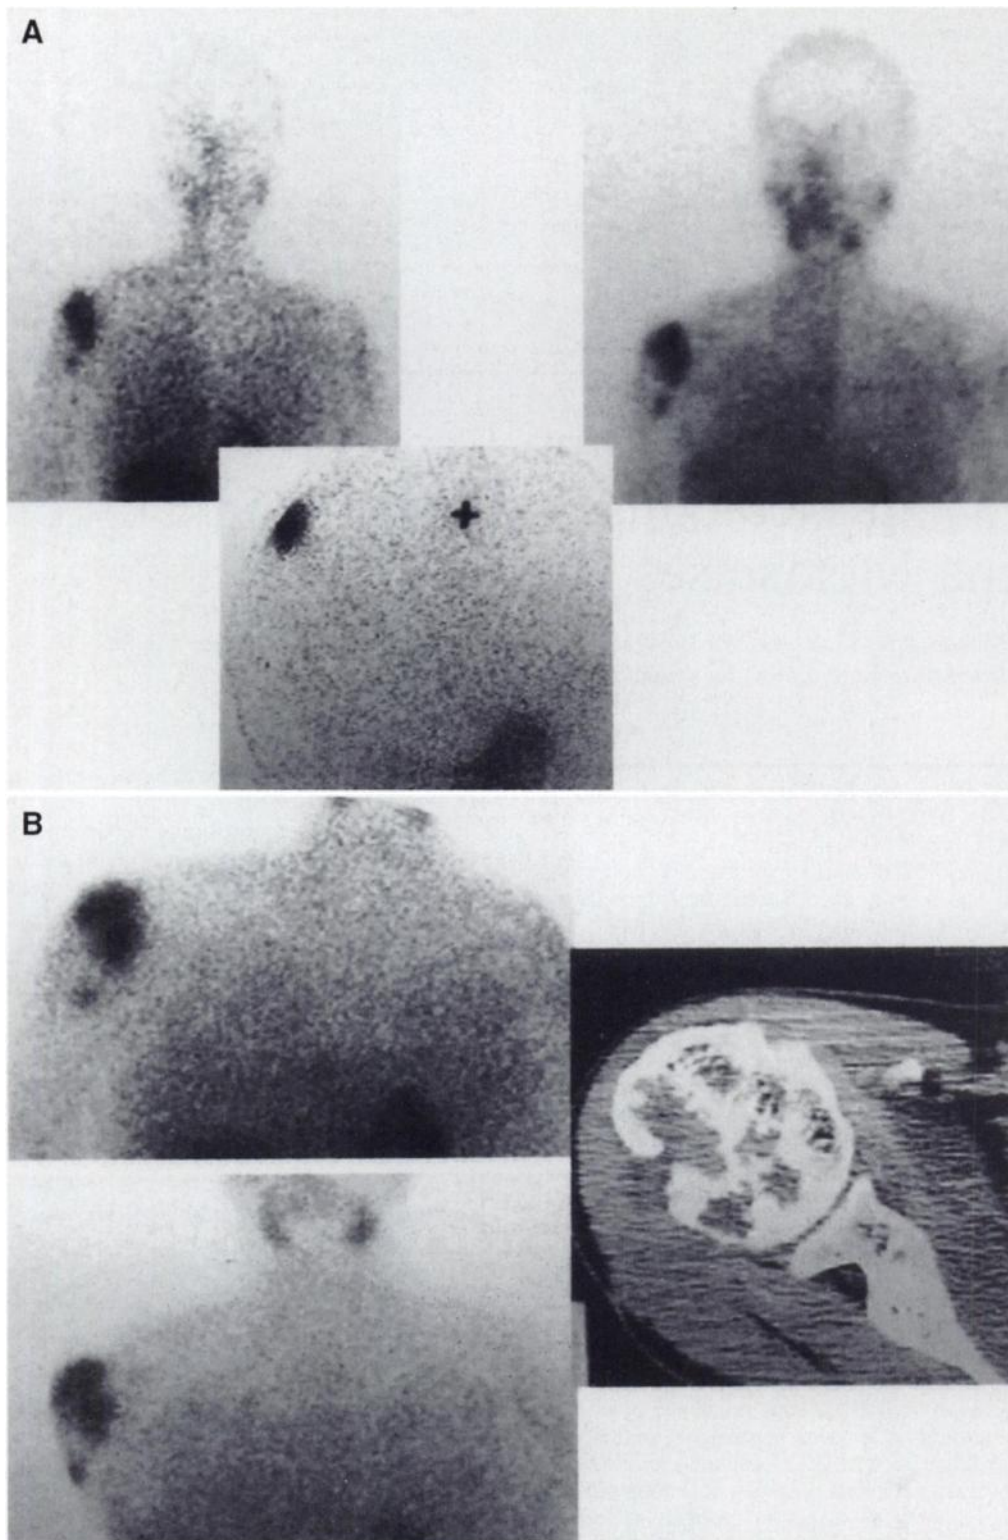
(A) A 31-yr-old woman with follicular thyroid carcinoma. Thallium-201 (left upper), ^{99m}Tc -tetrofosmin (right upper) and ^{131}I (lower) images show intense activity in right humerus in thyroxine-off images. (B) Thyroxine-on ^{201}Tl (left upper) and ^{99m}Tc -tetrofosmin (left lower) images of same patient. No difference to thyroxine-off images in site and lesion activity. CT (right) also confirms metastatic lesion in right humerus.
